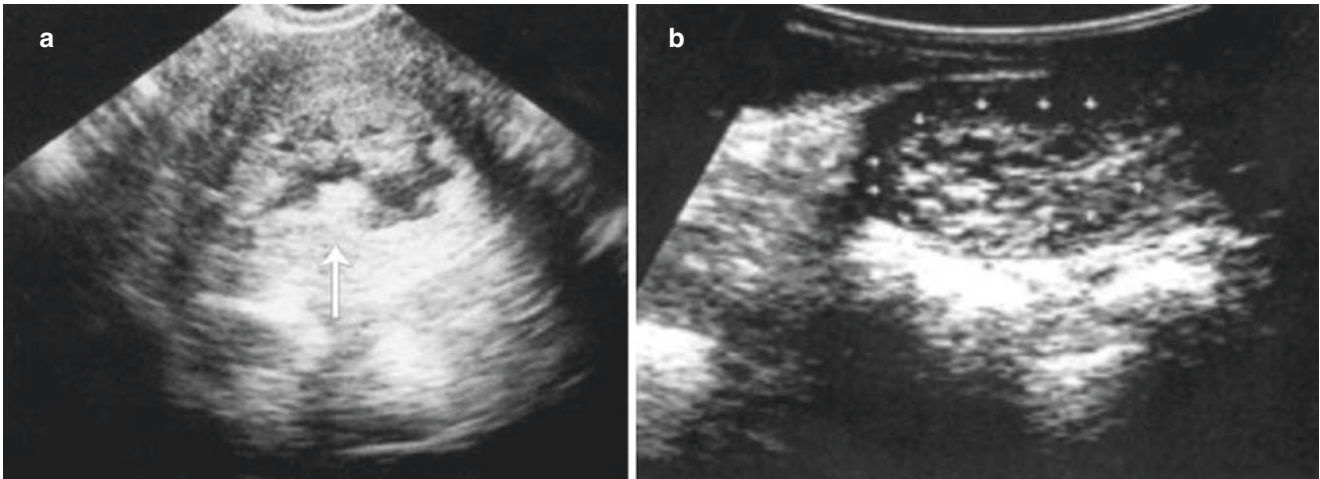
The differential diagnosis of endometrial polyp and tuberculosis. (a) A 37-year-old patient represented menstrual disorder with an excessive volume of menses for 2 years. Ultrasonography shows multiple irregular, heterogeneous hyperechoic masses in the uterine cavity;
